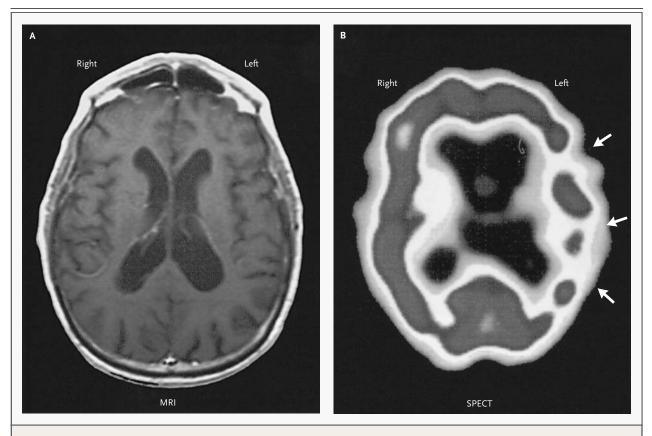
A Magnetic Resonance Imaging Scan (Panel A) and a Technetium Single-Photon-Emission Computed Tomographic Scan (Panel B) in a 73-Year-Old Man in the Early Stage of Primary Progressive Aphasia.
